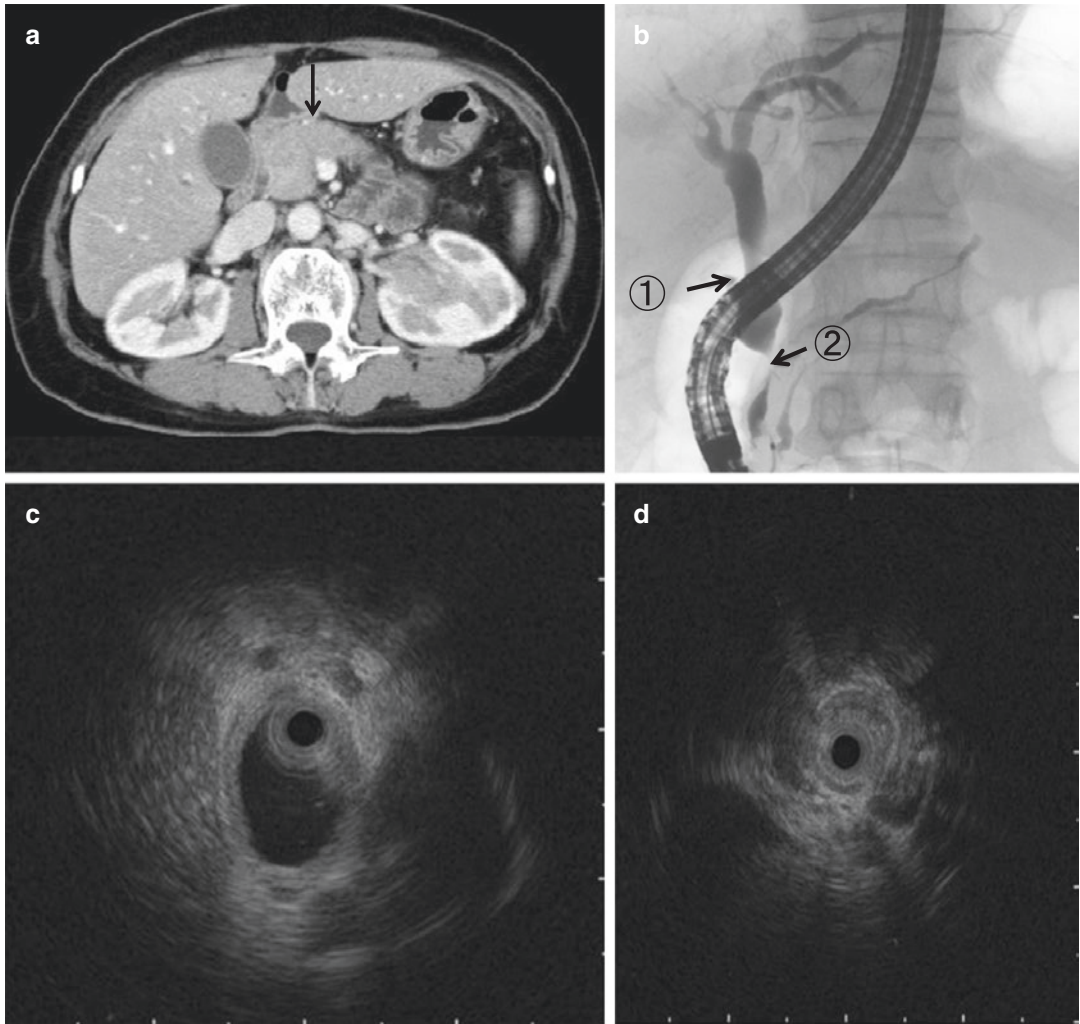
IgG4-related sclerosing cholangitis with a stricture in the lower part of the common bile duct (case 1, pretreatment). (a) Abdominal computed tomography image showing pancreatic swelling (arrow). (b) Endoscopic retrograde cholangiopancreatography image
